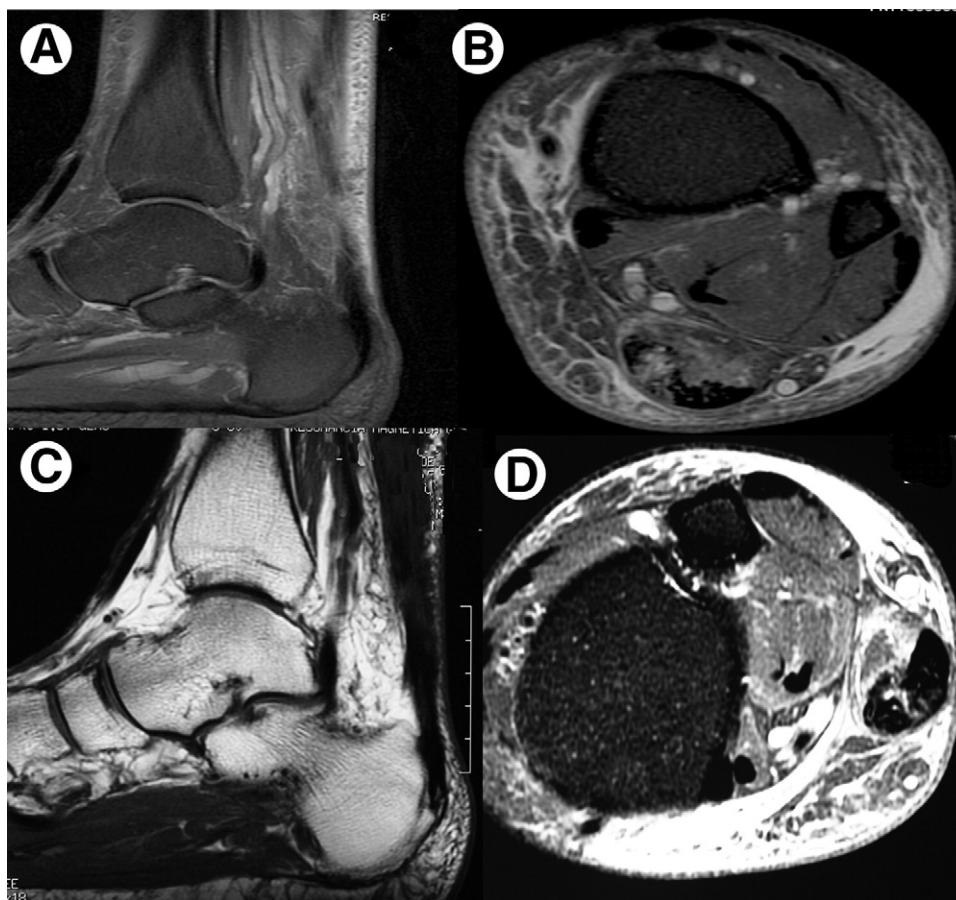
Achilles tendinopathy attributed to the oral use of corticosteroids in a 60-year-old man; after informed consent, the patient received 3 injections of PRP weekly. MRI showing (A-B) the pathologic area of tendon degeneration before PRP management; (C-D) Achilles tendon 2 months posttreatment.
